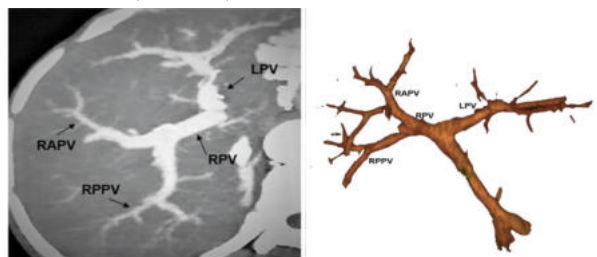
CT axial reformatted and VR image in portal venous phase showing classic anatomy of portal vein branching
